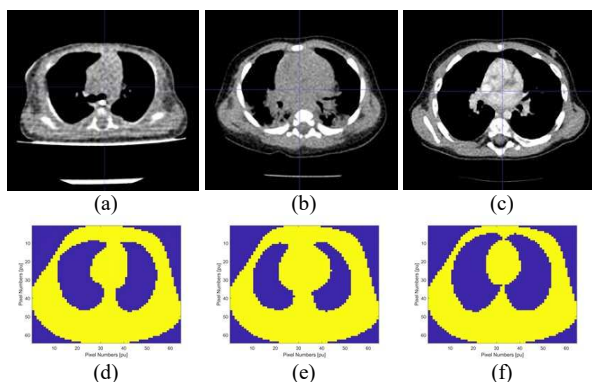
Cross-sections of three library models (a)-(c) CT scans at the plane of electrodes, (d)-(f) corresponding pixelised images sharing the same outer boundary.
